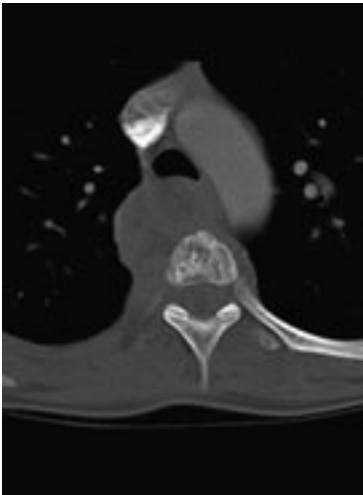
CT of vertebra T8 (axial, bone window). Extensive osteolysis of the vertebral body with paravertebral tumor masses isodense to soft tissue.
